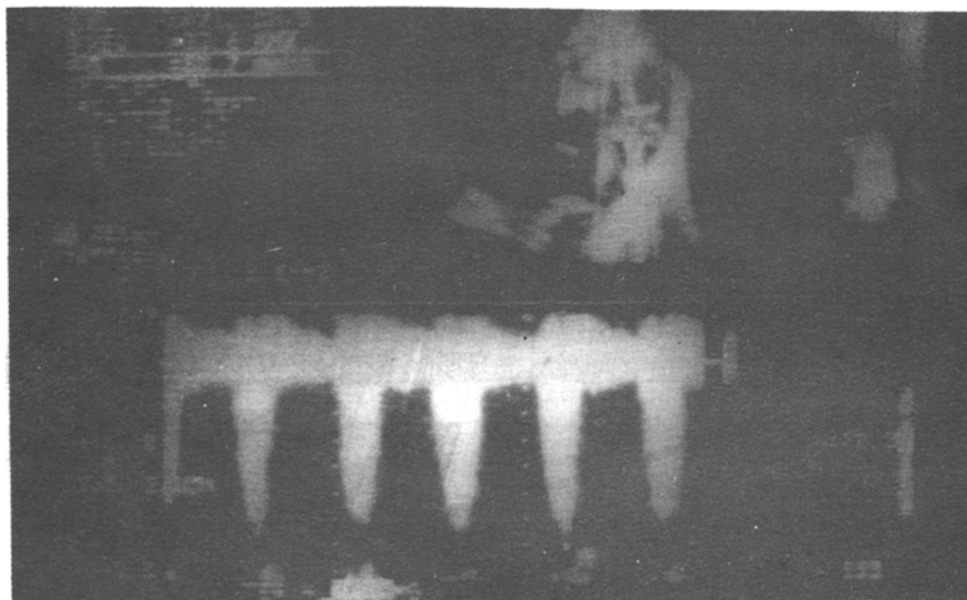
Short axis view of transthoracic echocardiography showing pulmonary valve [PV] and gradient across right ventricular outflow tract [ROVT] by Doppler velocity
